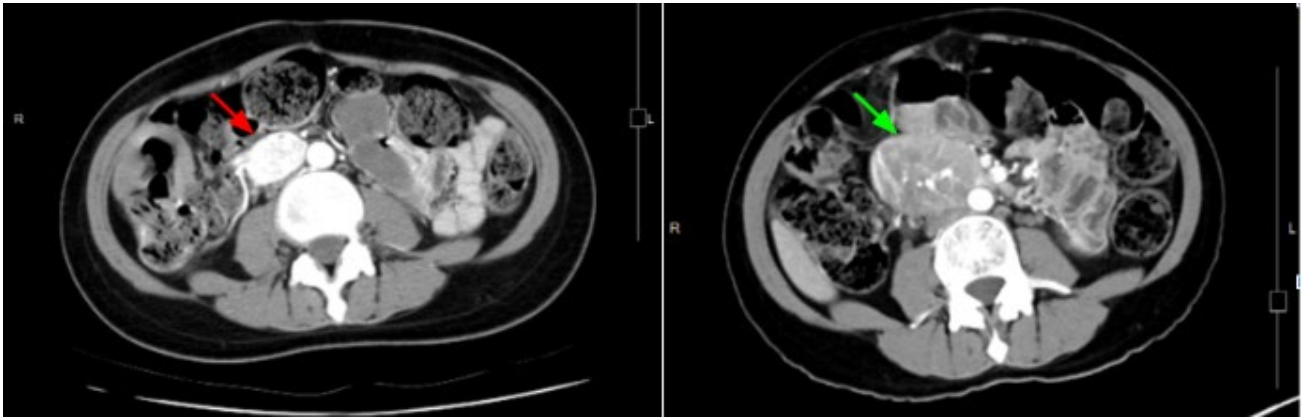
Abdomen CT shows the hypervascular soft tissue lesion in the aortocaval space in 2012 (red arrow, Left) that has enlarged to the huge retroperitoneal mass in 2016 (green arrow, Right) and later diagnosed as pheochromocytoma by surgical excision.
